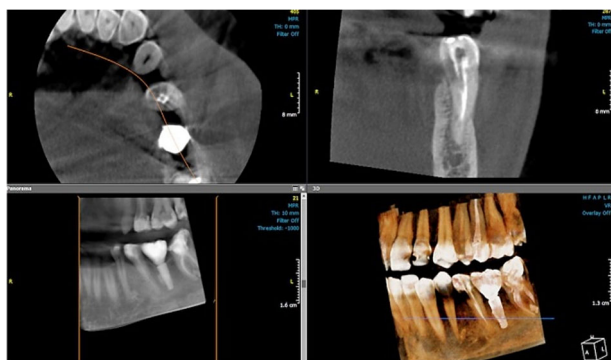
CBCT scans showing the true extent of the resorption in all three dimensions, being classified as a 2Bp class, according to Patel's classification.
